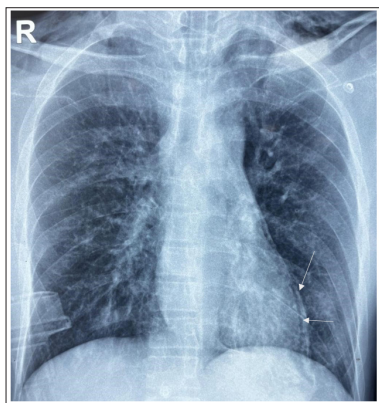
Admission Chest Radiograph Demonstrating a Radiolucent Halo Surrounding the Cardiac Silhouette (Halo Sign), Consistent with Pneumopericardium.
